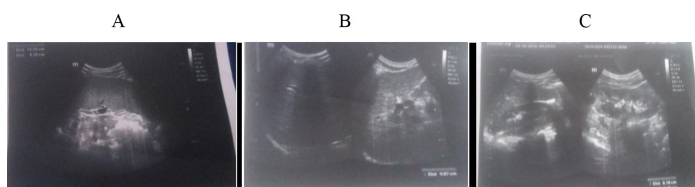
(A, B, C) Ultrasound images show splenomegaly, mild echotexture liver and normal kidneys.
